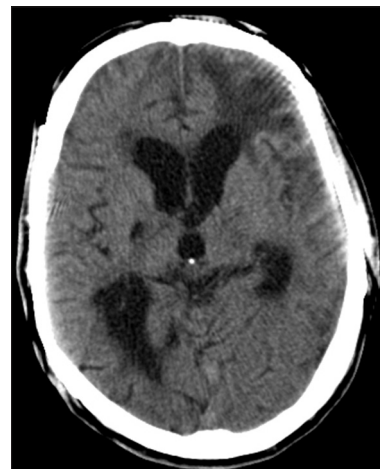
CT scan in a month after the cranioplasty
